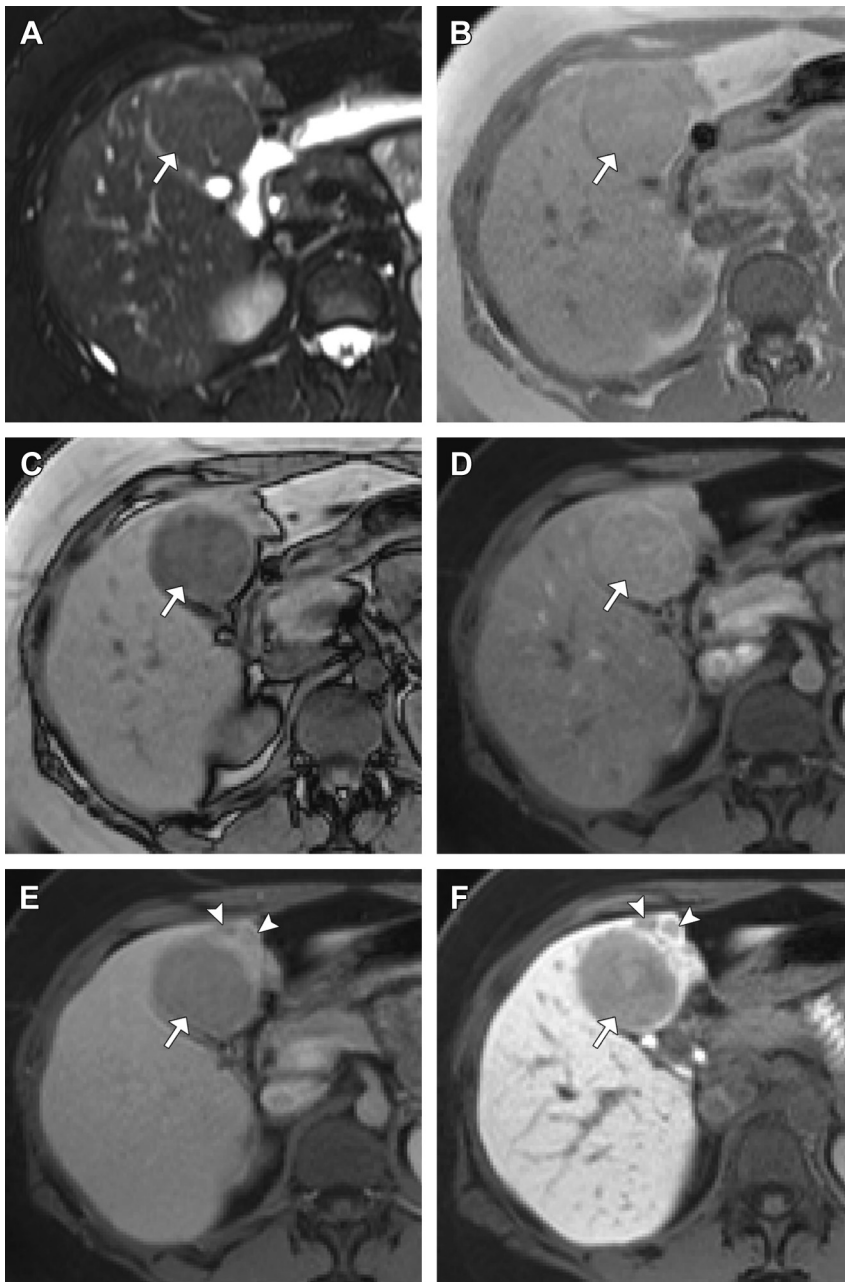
HCA (HNF-1 α -inactivated or steatotic subtype); gadoxetate disodium-enhanced MR imaging. (A) T2-weighted fat-suppressed image demonstrates a uniformly isointense hepatic mass (*arrow*). (B) The mass is isointense to liver on in-phase T1-weighted imaging (*arrow*). (C) Diffuse signal dropout of the mass on opposed-phase T1-weighted imaging indicates intracellular fat (*arrow*). (D) The mass uniformly enhances to a slightly greater degree than adjacent liver during arterial phase (*arrow*). (E) The mass becomes hypointense relative to liver during portal venous phase ("washout") (*arrow*); subtle small adjacent lesions also become apparent (*arrowheads*). (F) The dominant mass (*arrow*) and small adjacent lesions (*arrowheads*) all remain hypointense to liver during hepatocyte phase, with the small lesions best seen on this series. Multiple HCAs were confirmed at resection.
